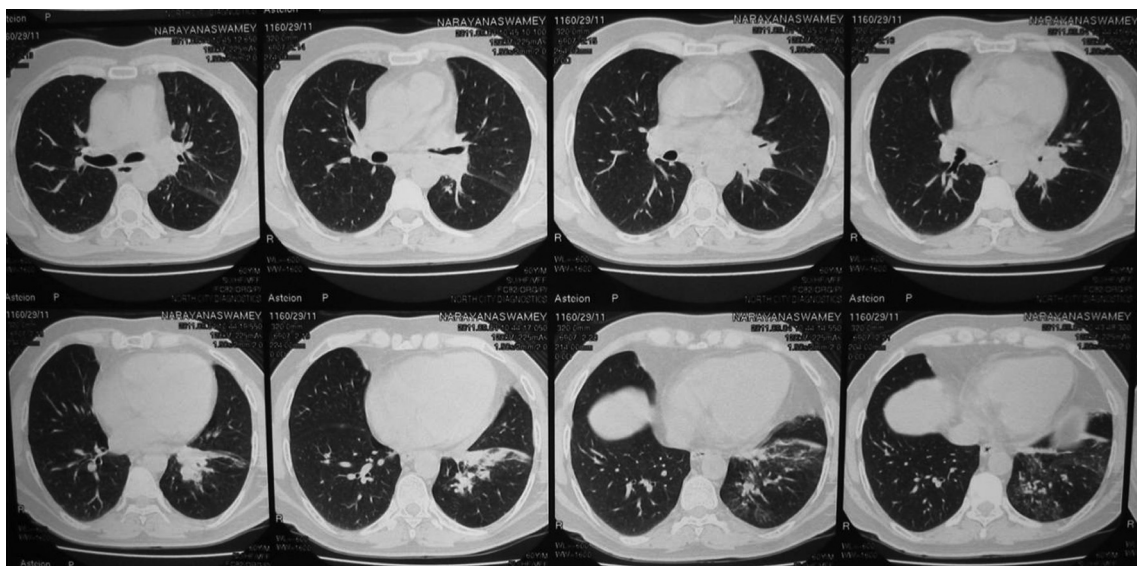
CT Thorax showing peribronchial lesion on left side with considerable narrowing of the left main bronchus with infiltrates in the lower lobe.
